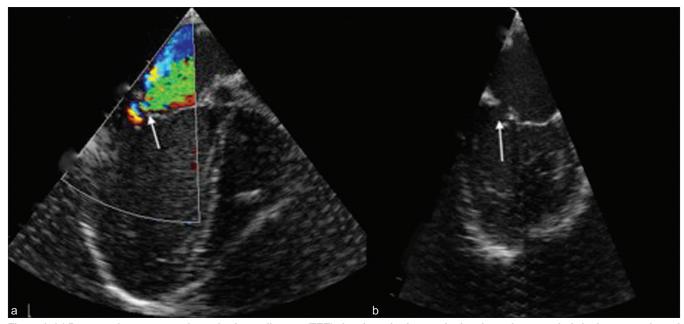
(a) Preoperative trans-esophageal echocardiogram (TEE) showing mitral regurgitation through a 4-mm hole in the posterolateral leaflet. (b) Preoperative TEE revealing a perforation in the posterior leaflet of the mitral valve
